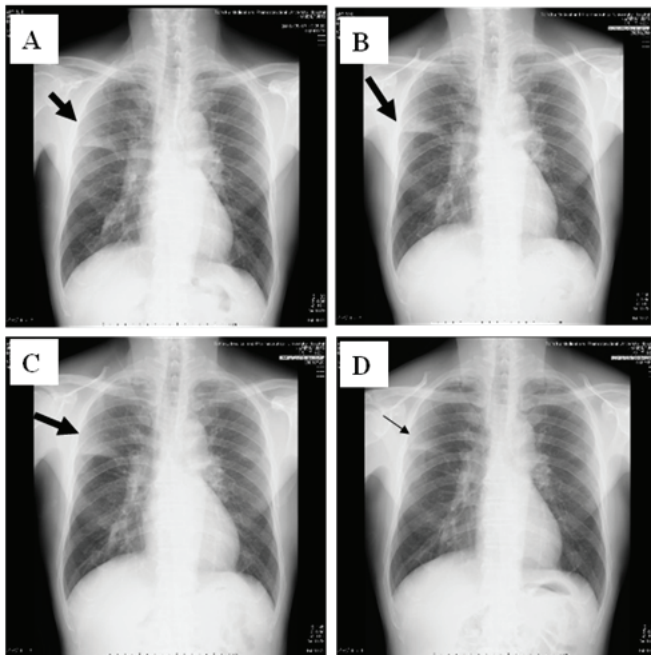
Chest X-ray changes of the patient. A: Day1, B: Day 4, C: Day 7, and D: Day 11, respectively. The infiltration shadows on right upper field did not changed at Day 1 and Day 4, but worsened at Day 7. However, they were improved at Day 11 after methylprednisolone were used.
